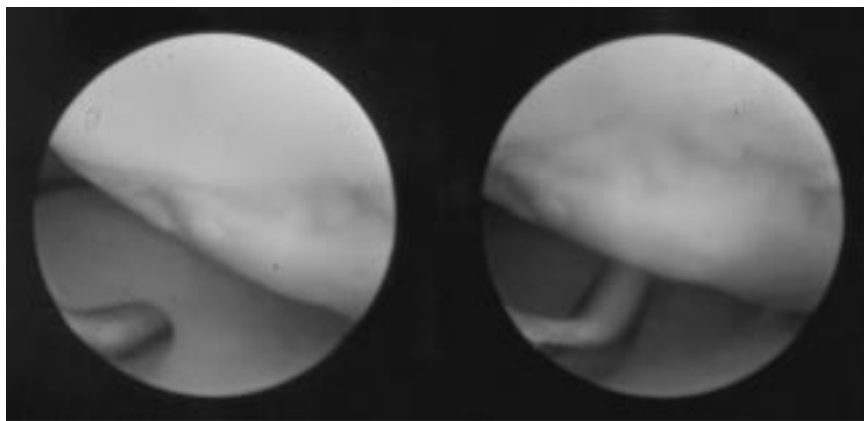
Typical chondral lesion well shown by arthroscopy, but not well demonstrated by MR imaging.
